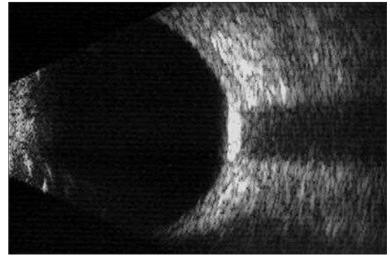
B-Scan Ultrasonography of Choroidal Osteoma Showing Dense Plate-Like Lesion That Shadows the Sclera and Orbital Soft Tissues Behind It.
